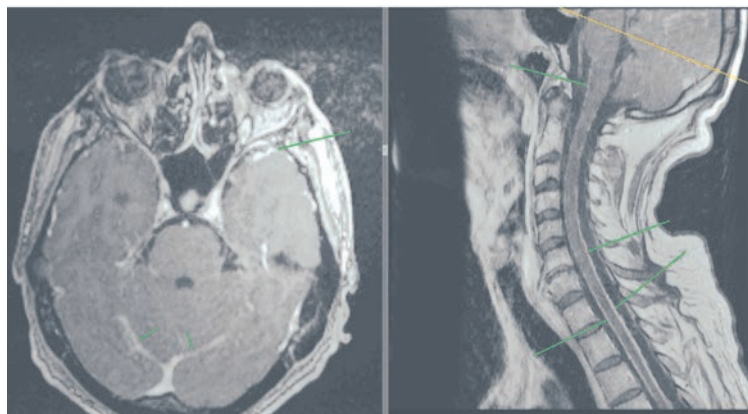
Multislice Computed Tomography of the Brain. Axial T1-weighted image of the brain and sagittal T1-weighted image of the cervical spine were performed after the administration of the contrast agent. Multiple areas of enhanced MR signal from the pia mater of the brain and spinal cord.
